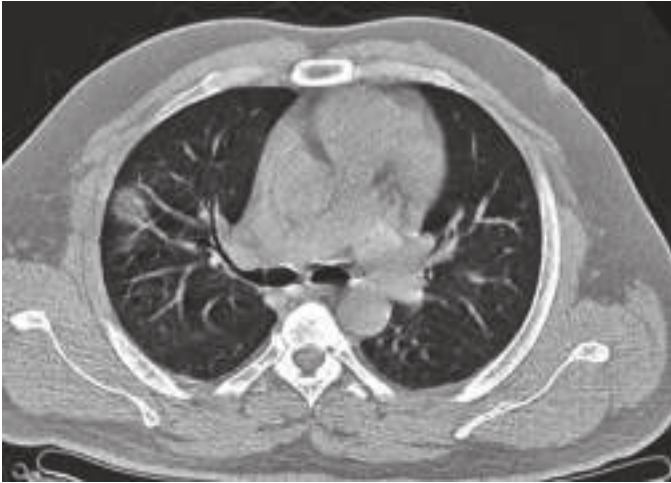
Computed tomography scan demonstrates lungs involvement in a patient of SARS-CoV-2 (COVID-19 disease). (Courtesy: Dr. Vigyat, Dr. DY Patil Medical College, Pune, Maharashtra).
